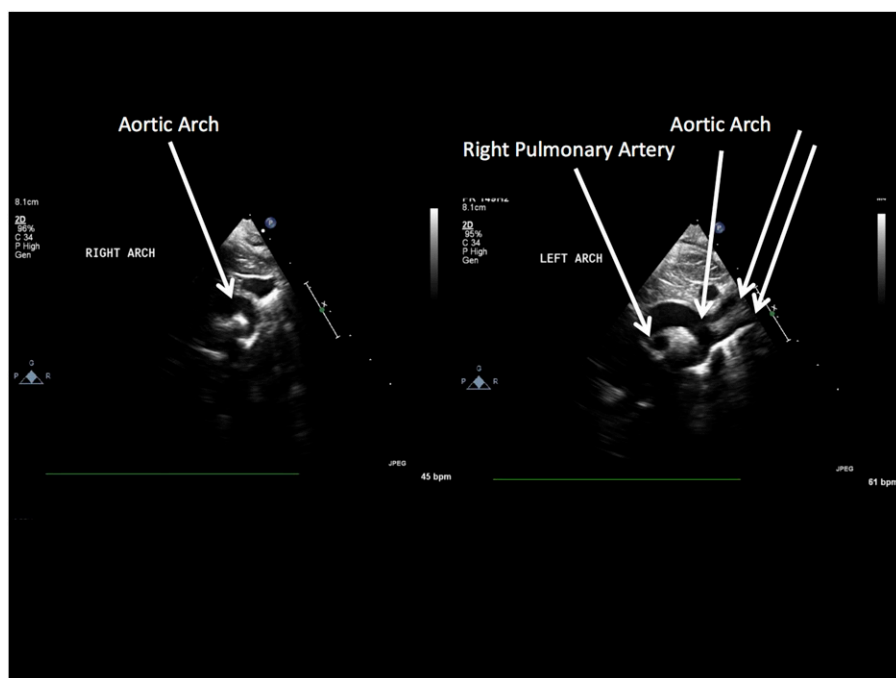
Echocardiogram of right and left aortic arches.
